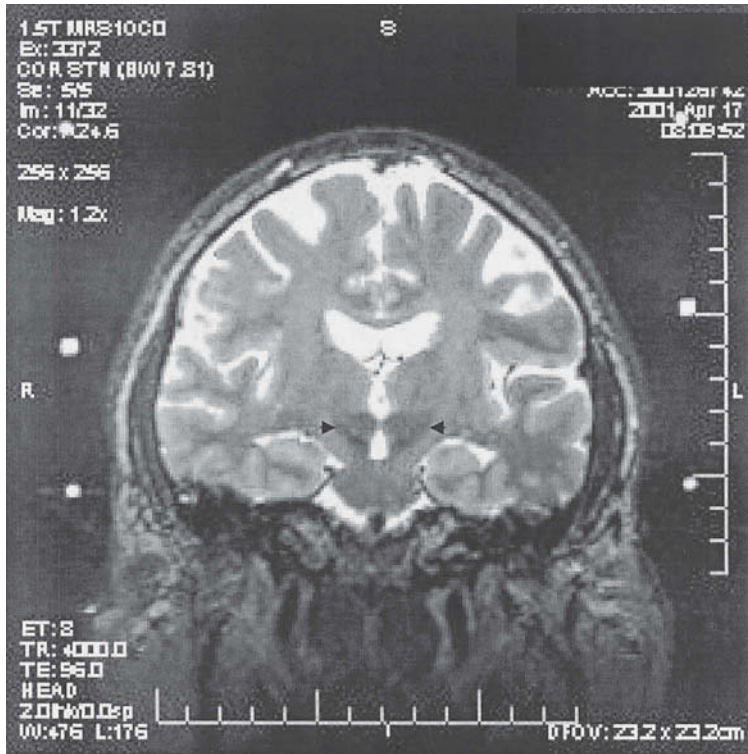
T2-weighted coronal image for direct targeting of the subthalamic nuclei bilaterally (arrowheads). Notice that the substantia nigra lies ventromedial to the STN, the red nucleus lies dorsomedial, and the internal capsule runs lateral to the STN as it projects inferiorly toward the cerebral peduncle.
